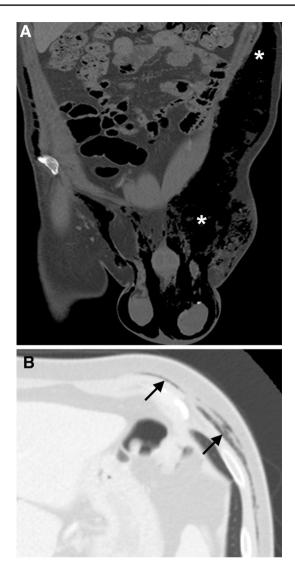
Fournier gangrene with extension to the abdominal wall and chest wall. a Coronal enhanced CT image shows extensive soft tissue gas involving the scrotum, bilateral inguinal areas, and left anterior abdominal wall (*). b Axial enhanced CT image in lung window demonstrates soft tissue gas along the left anterior thoracoabdominal wall (arrow)
